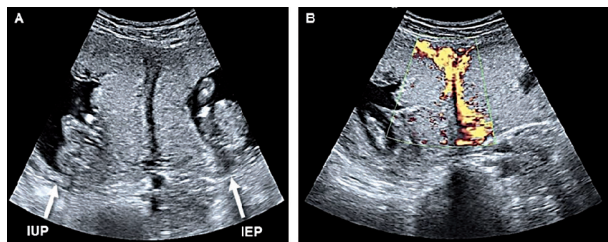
Two-dimensional gray scale transverse section showing the intrauterine pregnancy (IUP) and the left interstitial pregnancy (IEP) (Panel A). Color Doppler imaging shows two different trophoblast layers between intrauterine and ectopic pregnancies (Panel B).
